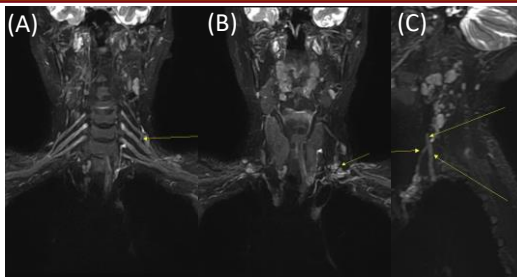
Coronal (A, B) and sagittal (C) image of brachial plexus MRI and nearby anomalous dorsal scapular artery. (A) Left dorsal scapular artery (arrow) traverses between left C5 and C6 nerve roots. (B) The left dorsal scapular artery originates from left subclavian artery. (C) Sagittal image of brachial plexus crossing left dorsal scapular artery.
